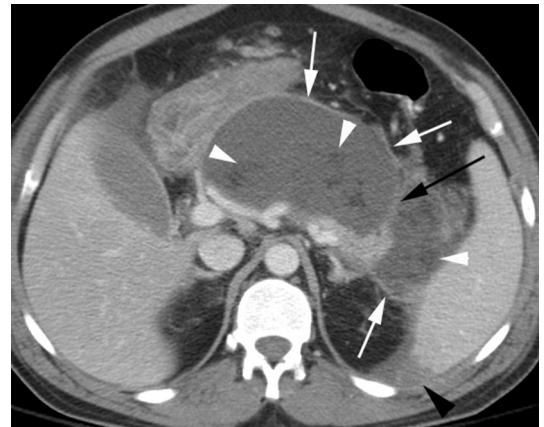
WON in necrotizing pancreatitis. The axial CT image in this 27-year-old man demonstrates a large fluid collection with an enhancing capsule (*white arrows*) that involves the pancreatic parenchyma and extrapancreatic space. The collection contains areas of necrotic fat (*white arrowheads*) and septations (*black arrow*) and represents the combined form of necrosis after 6 weeks from onset of symptoms. Also, an extrapancreatic complication is seen in the form of a small splenic infarct (*black arrowhead*).
